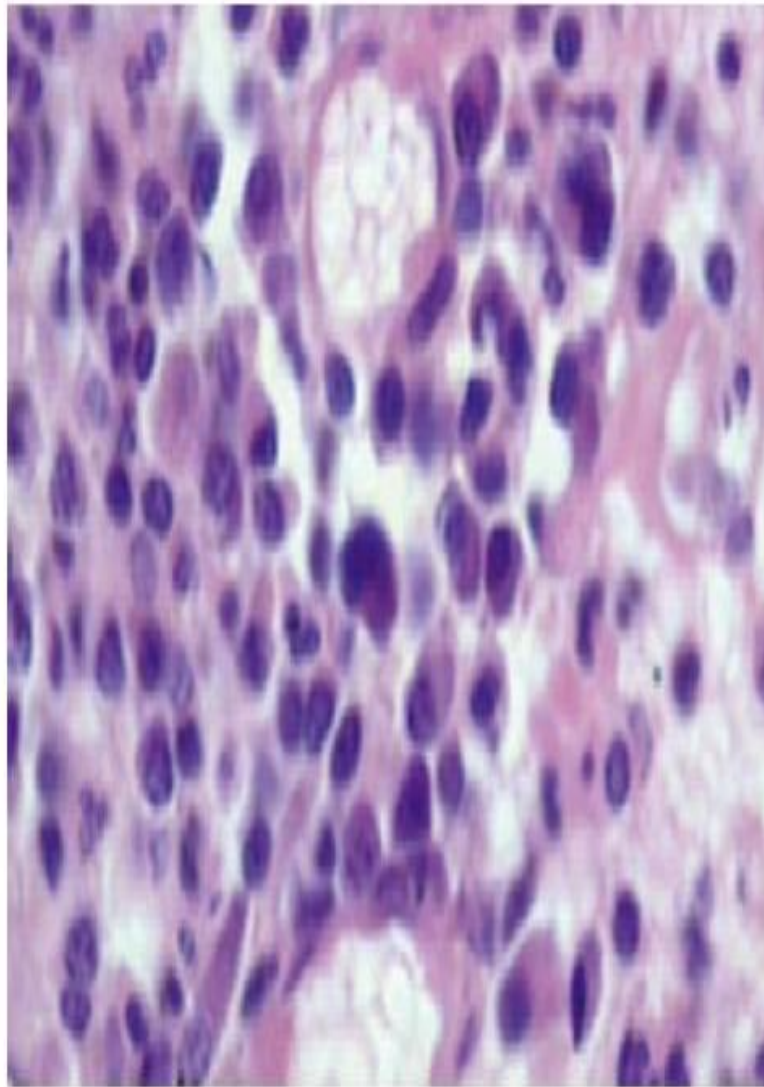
Periapical granuloma
